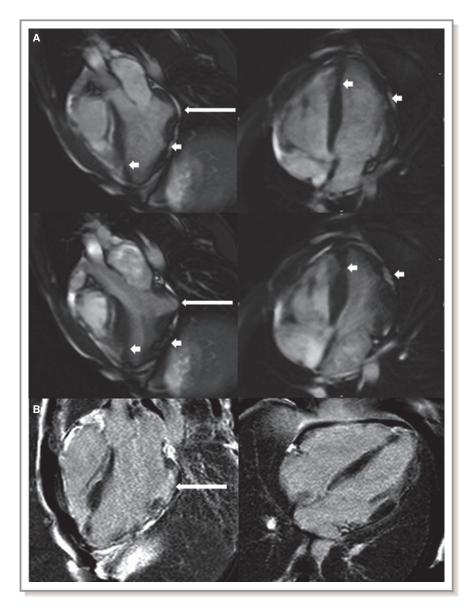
A, Cardiac magnetic resonance imaging 3-chamber and 4-chamber views at end-diastole (top panels) and end-systole (bottom panels) of a homozygote showing a basal inferolateral aneurysm (long arrow) with additional focal areas of thinning and akinesis in the apex, apical septum, apical anterior, and mid anterolateral walls (short arrows). There were no right ventricular abnormalities. B, Corresponding views showing small regions of late gadolinium enhancement at the edge of the basal inferolateral aneurysm (long arrow).
